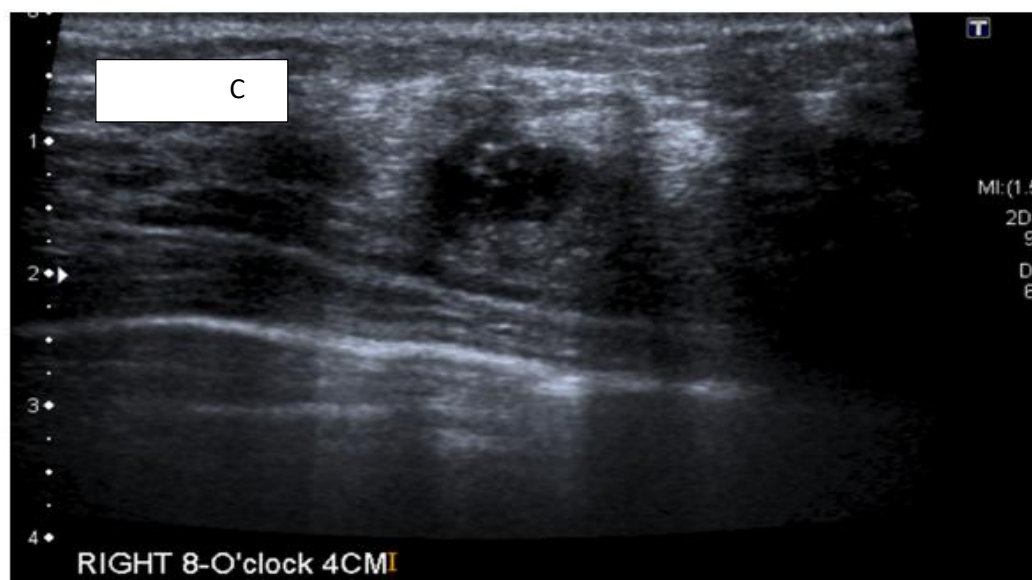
Ultrasound revealing multiple areas of ill-defined mixed hypo-and hyper echoic changes within the right breast, most pronounced in the 8:00 position (Medical Imaging, 2020)
